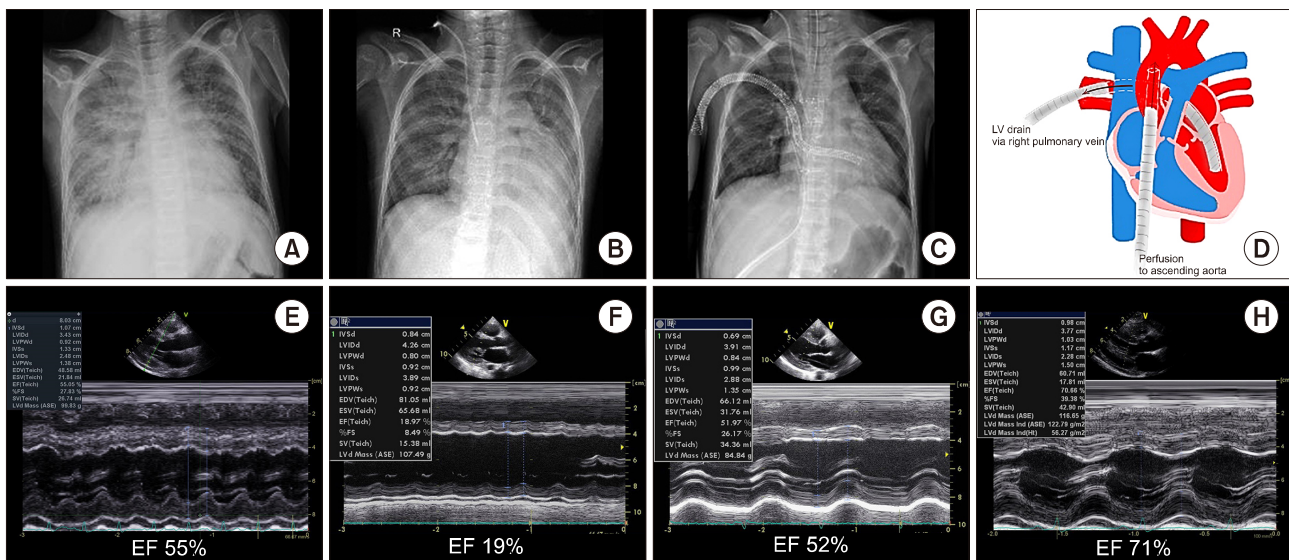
Serial chest radiographs and echocardiograms. Chest radiographs on HD13 (A), HD20 (B) showed cardiomegaly and pulmonary congestion progressed, LVAD was applied on HD21 (C, D). Echocardiograms showed a rapid recovery of ventricular function after LVAD insertion; HD16 (E), pre LVAD insertion (F), 7 days after LVAD insertion (G), and post LVAD removal (H).
